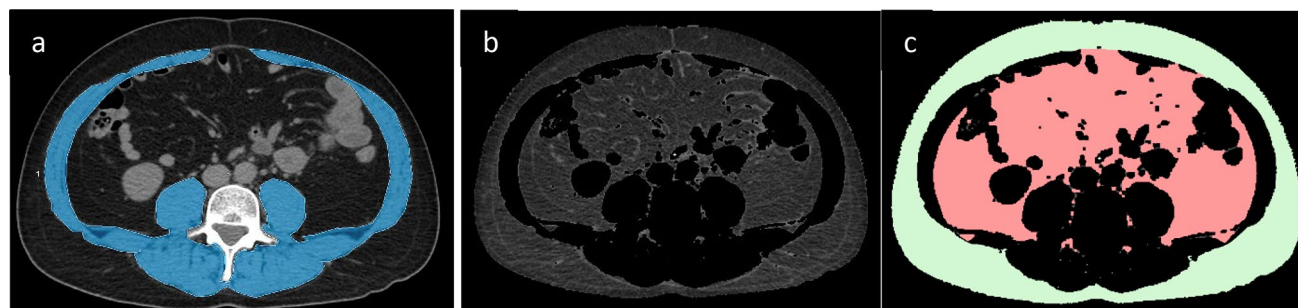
Axial CT images at the L3 level highlighting the selected muscle compartment (a: blue) and the adipose tissue (b: grey) divided into subcutaneous adipose tissue (c: green) and visceral adipose tissue (c: pink) for the calculation of body composition parameters
